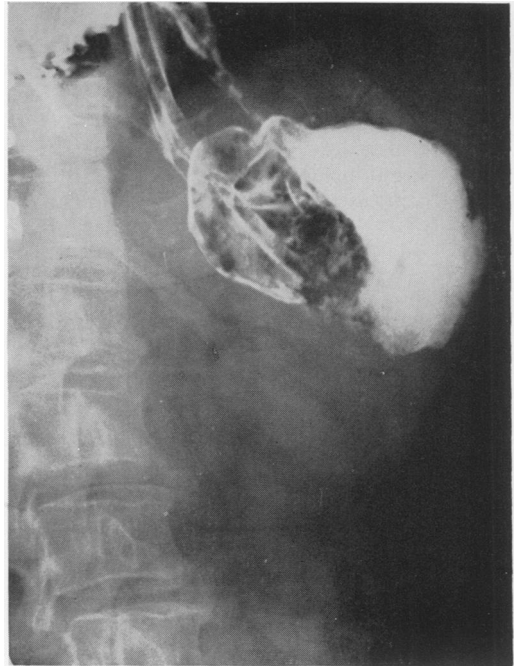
(Case 12). This x-ray is of interest since it demonstrates the Levin tube lying within the proximal dilated segment allowing for decompression with relief of obstructive symptoms. Another example of partial organo-axial volvulus.
